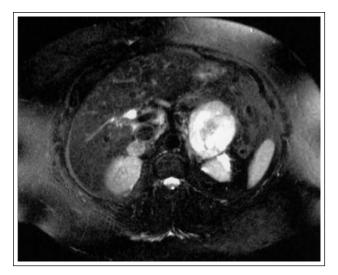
MRI shows a 7.8 cm mass intimate to the left adrenal gland with very bright fat saturated T2-weighted images raising the probability of a pheochromocytoma.
